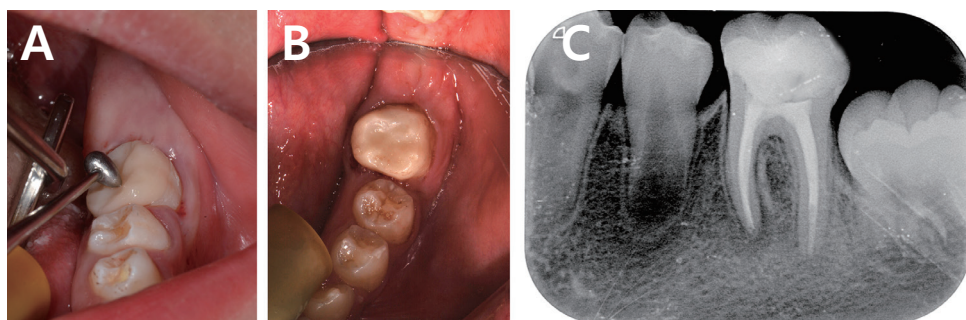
(A) Conventional adhesive system is used to bond the endocrown to the prepared tooth, (B) Occlusal view after final cementation, (C) Radiographic image after cementation and polishing.
